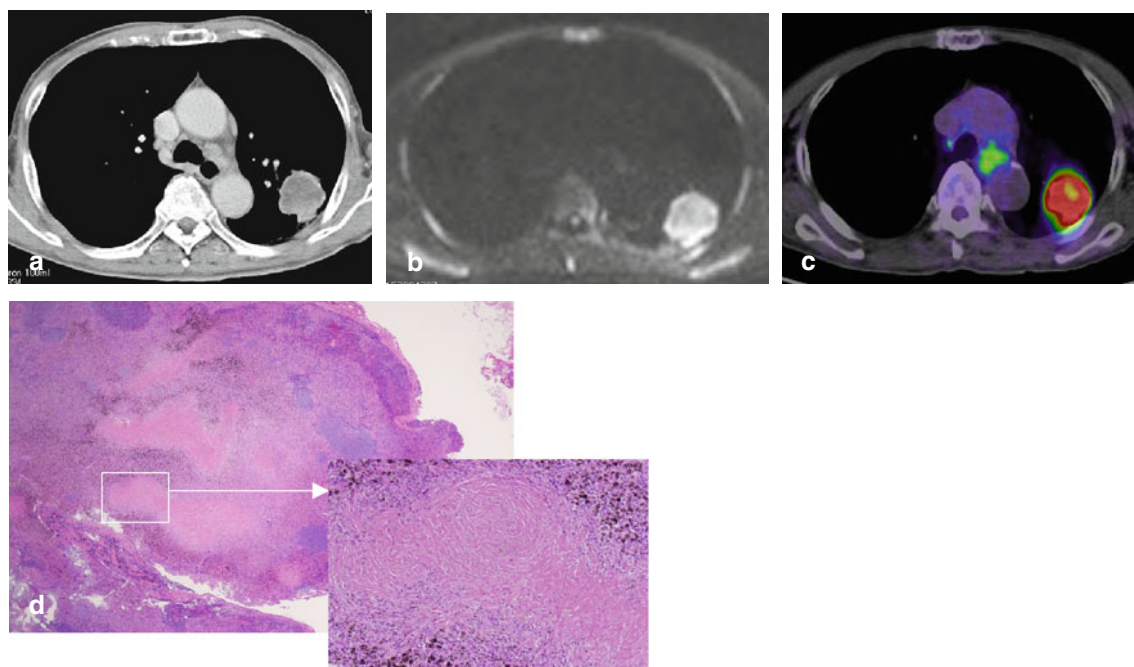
Chest CT (a), DWI (b), and PET-CT (c) of one patient with large cell carcinoma. DWI and PET-CT identified the malignant lesion clearly. FDG accumulation (SUVmax: 4.39) in a #4L lymph
